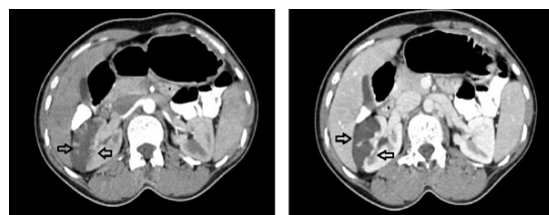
and FIGURE 5: On axial contrast enhanced CT scan the right kidney shows multiple non-enhancing cystic lesion in the mid and lower pole with a HU value of 6 suggesting clear fluid .There was no evidence calcification or bleed within the lesion . There is no evidence of perinephric fat stranding.
